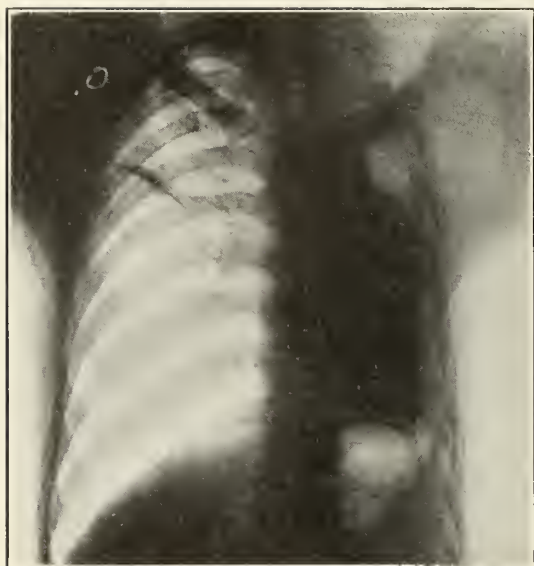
Beginning April 20, 1930, a two-stage paravertebral thoracoplasty performed. Roentgenogram, taken September 11, 1930, shows two thirds of larger cavity closed. In October, 1930, after some spitting of blood, did a parasternal anterior costectomy of the 2nd, 3rd and 4th ribs. (See figure 3.)
